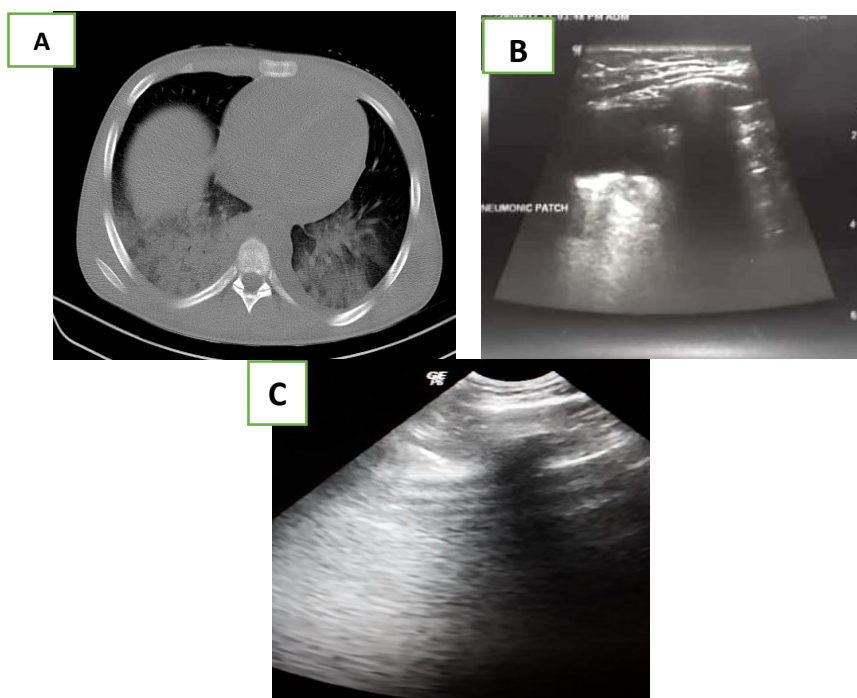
A 17 years old male patient, complained with fever, tachypnea and dyspnea (A) Post contrast CT lung window axial cuts revealed: Area of increased pulmonary attenuation with air bronchogram seen in basal segment of both lower lobes.(B and C) Chest US images showed bilateral basal increase lung echogenicity . Diagnosis: Bilateral basal posterior consolidation with air bronchogram (pneumonic consolidation)
